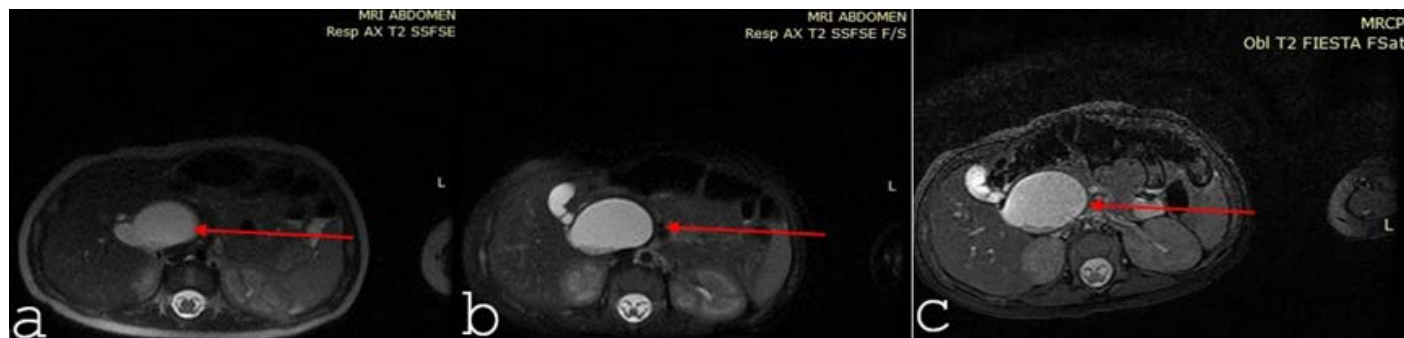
A 2-day old male neonate with atypical type IVA right hepatic duct cyst. Axial magnetic resonance imaging T2-weighted Single-Shot Fast Spin Echo (a) and fat saturation (b, c) images, demonstrating a 30×38 mm cystic lesion arising from the right hepatic duct, well differentiated from the adjacent gallbladder (red arrows).
